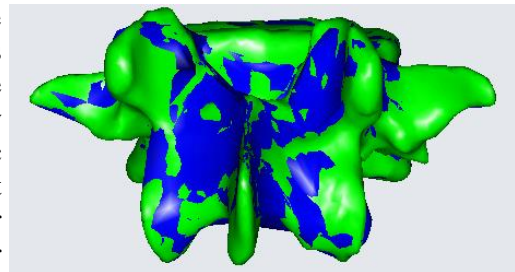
The result of morphing -Green target L4 CT based with the blue transformed generic STL L4 vertebra.
